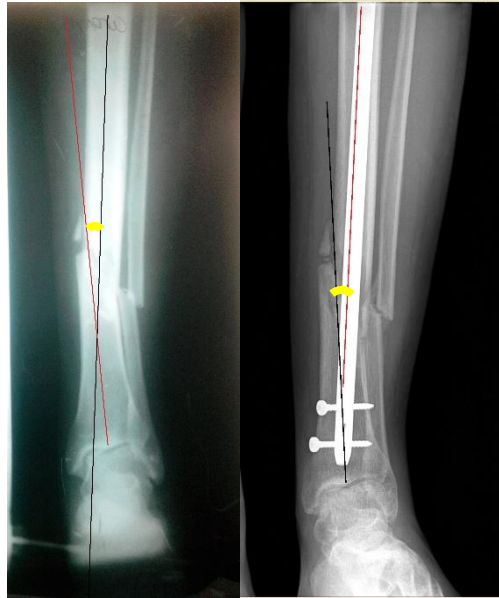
Six weeks post-op radiograph of 2<sup>nd</sup> patient
